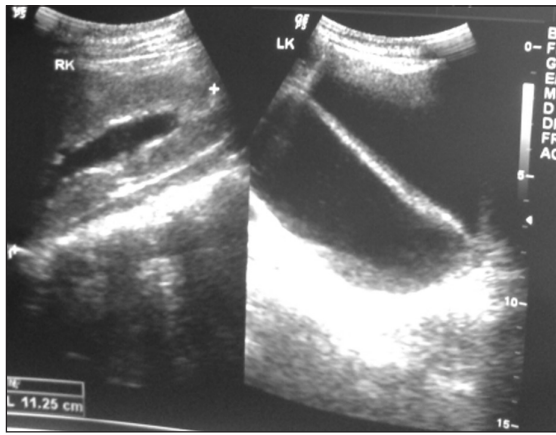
Ultrasound Kidney Ureter Bladder (KUB) showing left hydronephrosis
